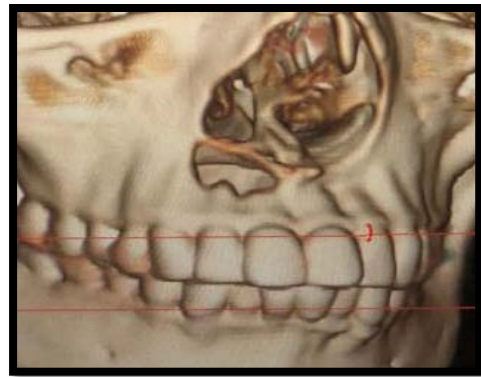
CT image showing labial perforation
